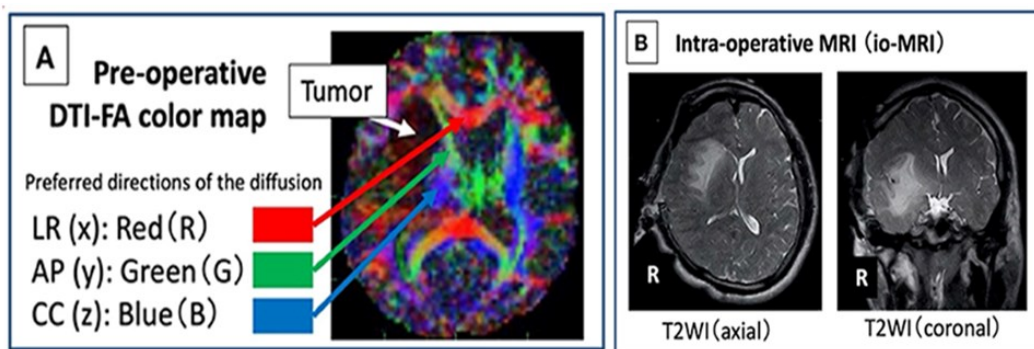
Examples of images obtained preoperatively with assistance intraoperative MRI (B) and intraoperatively with assistance Diffusion tensor imaging MRI (A) Source: [15].
